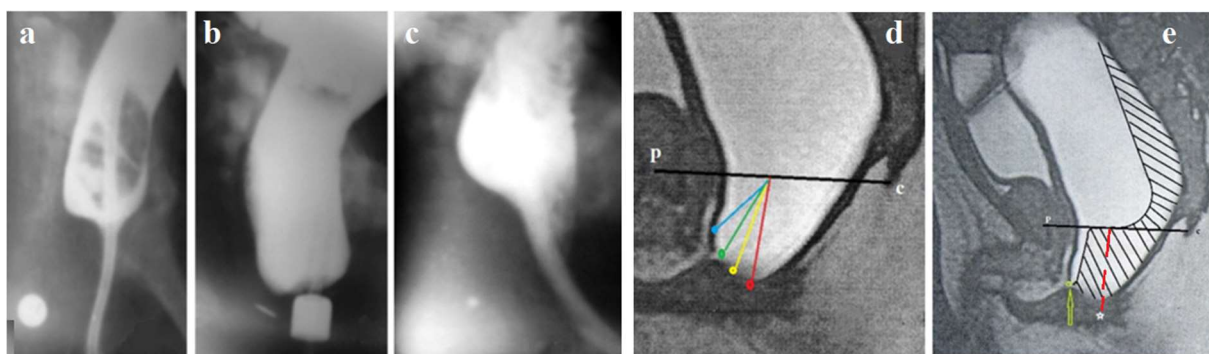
X-ray functional studies in patients with ARMs. (a) Lateral radiograph of a patient with vestibular ectopic of the anus. The anal canal has closed around the catheter through which barium was injected into the rectum. A pin is glued to the anal dimple. (b) During a repeat hospitalization, the same patient experienced anal canal disclosing during a contrast enema while attempting to defecate. Since the diameter of the contrast marker located near the fistula
